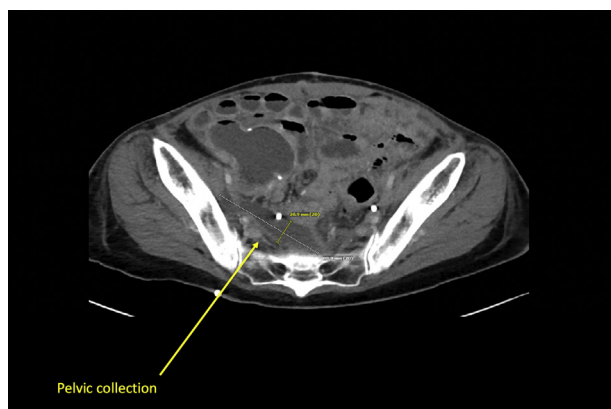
CT view of the abdomen and pelvis showing a pelvic collection.
